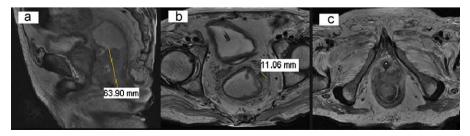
Magnetic resonance imaging scan of the pelvis showing: (a) Solid mass measuring 63 mm in length and 53 mm × 33 mm in diameter, (b) perirectal lymph node 11 mm in diameter, and (c) invasion of the internal anal sphinter.
